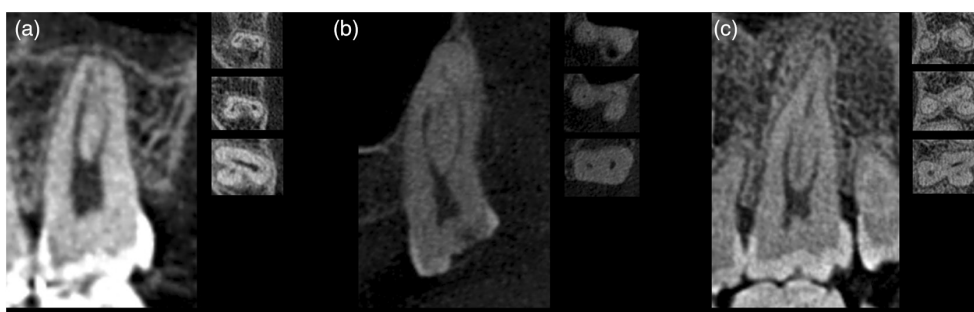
Axial views (representative coronal, middle and apical CBCT slices from bottom to top) demonstrating a selection of internal variations of the mesiobuccal roots of three-rooted maxillary second molars. Single canal configurations ((a) Vertucci type I) in the mesiobuccal root were seen in approximately one-third of the teeth studied. Additional canal anatomy, such as MB2 canals ((b) Vertucci type IV) or at times even three canals ((c) Vertucci type XVIII) were observed in more than two-thirds (67.4%) of the sample.
